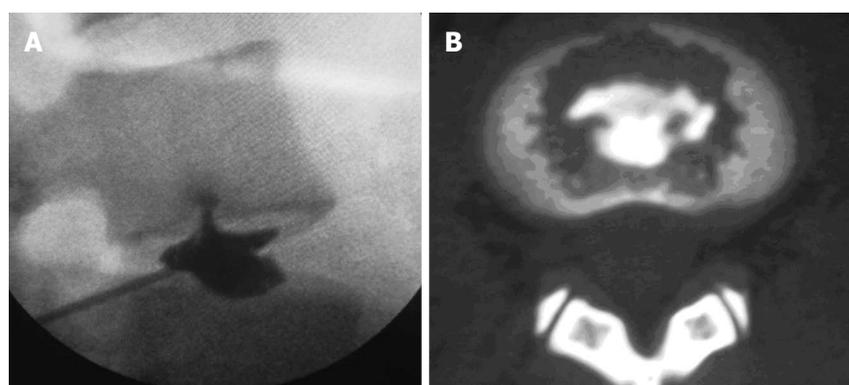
Discography and computed tomography. A: Discography showing a radial disruption on the lower endplate of L4 vertebra and that the contrast medium flows into the cancellous bone of the lower endplate of L4 vertebra through the fissure; B: Computed tomography scan showing the contrast medium dispersed in the lower endplate of L4 vertebra, with Grade 4 endplate disruption.
